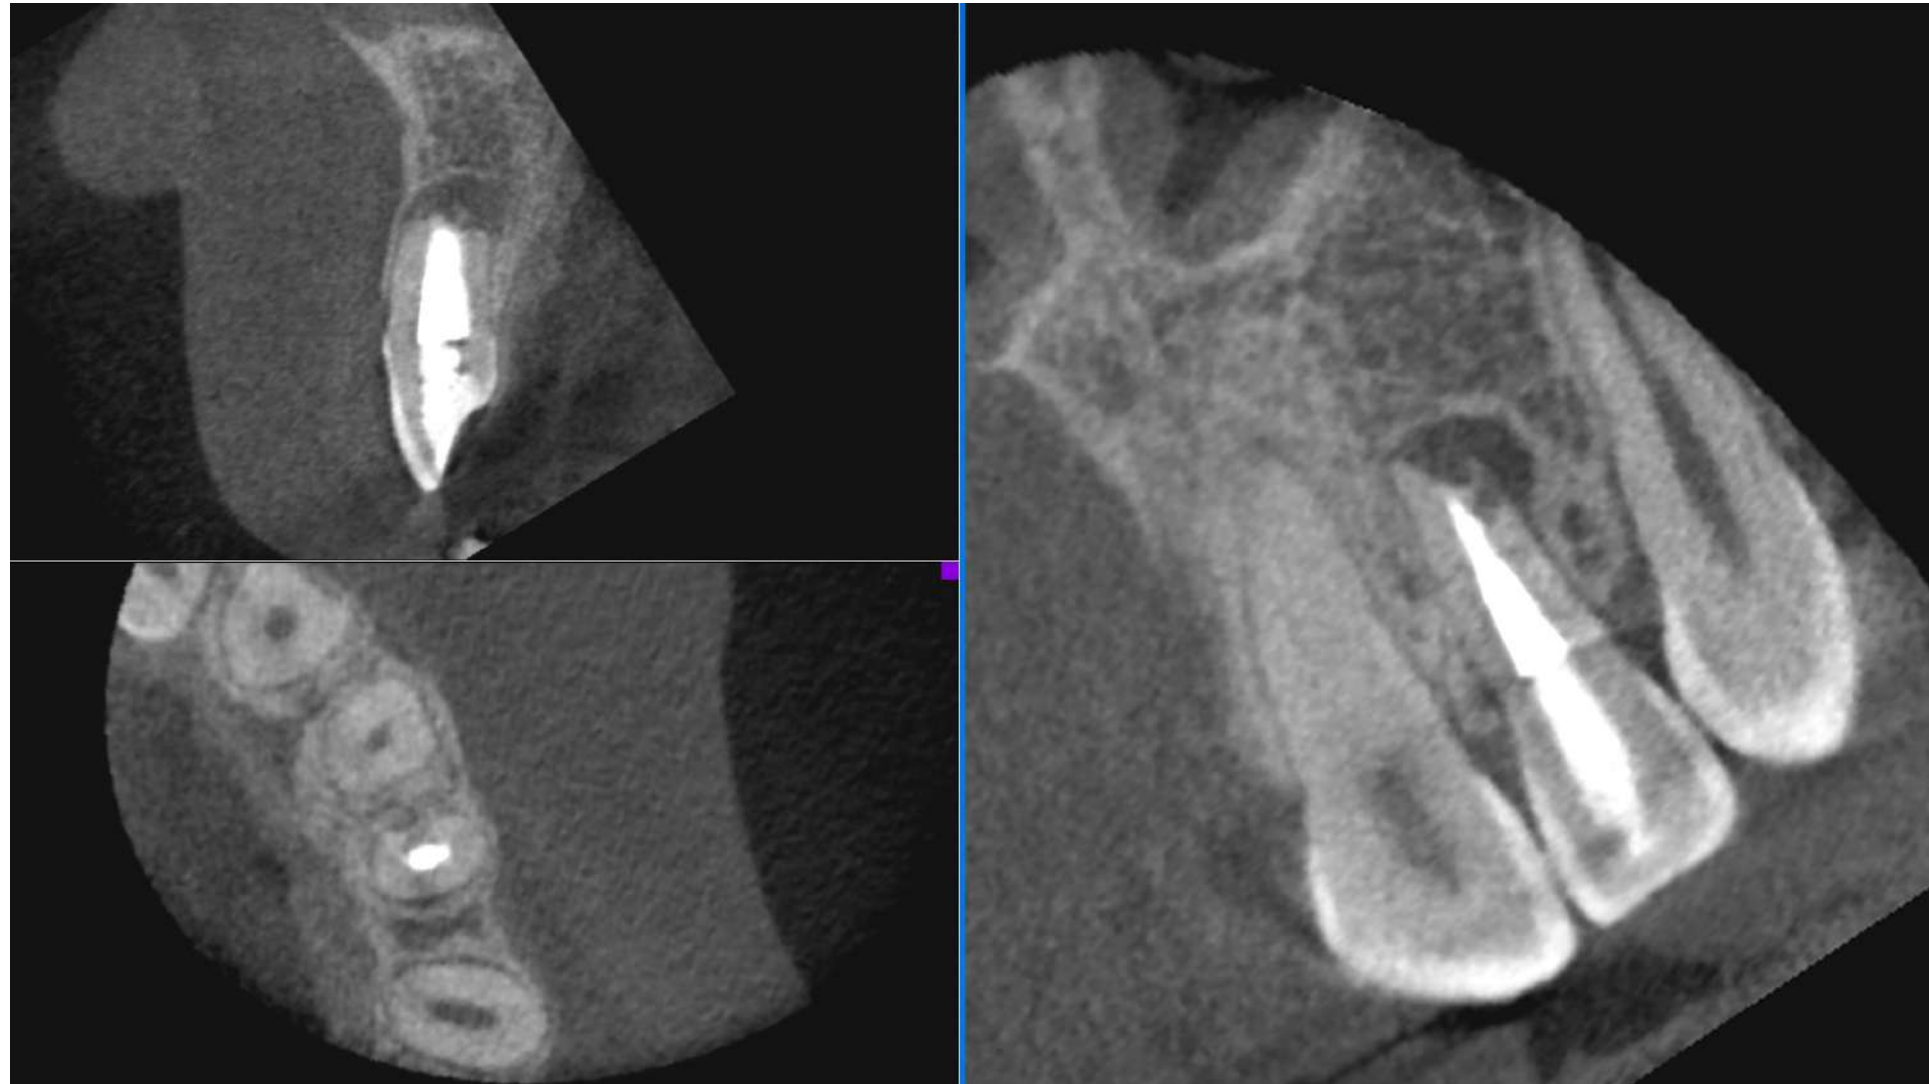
Two years follow up (one year after the surgery) CBCT show significant decrease in the lesion size
